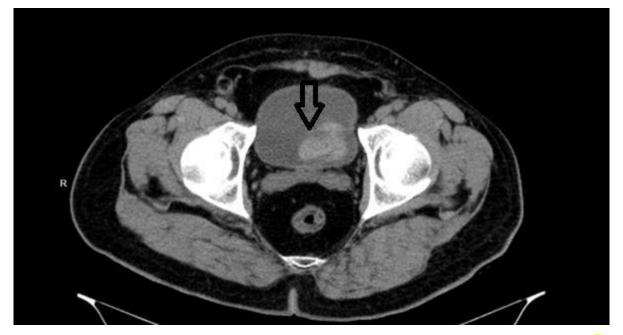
Computed tomography image of metachronous metastasis shown with the arrow.
